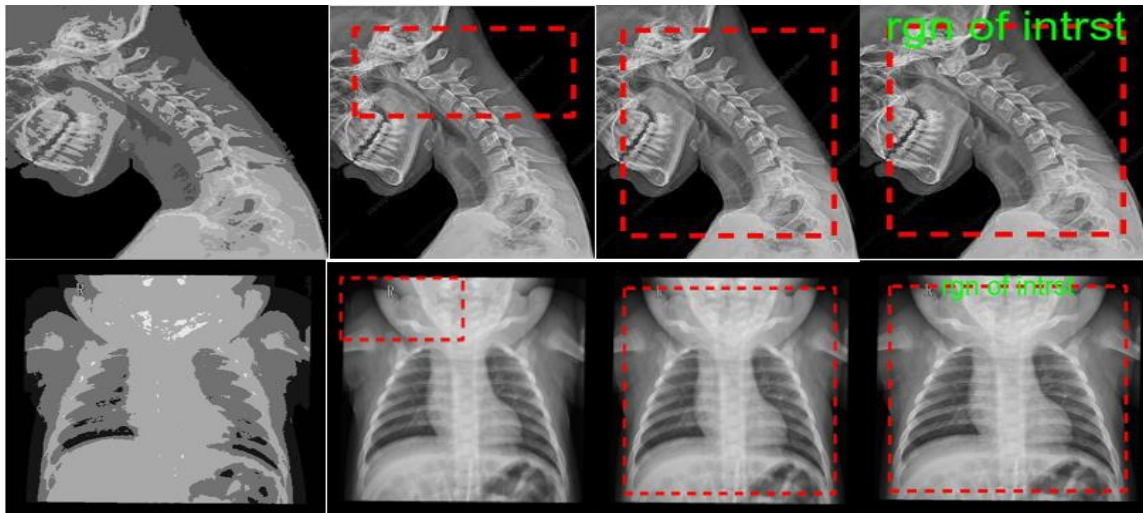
Neck and chest radiograph basic segmentation; from left, oiled view image, small area segmented image, large area segmented image and labeled area of interest.
